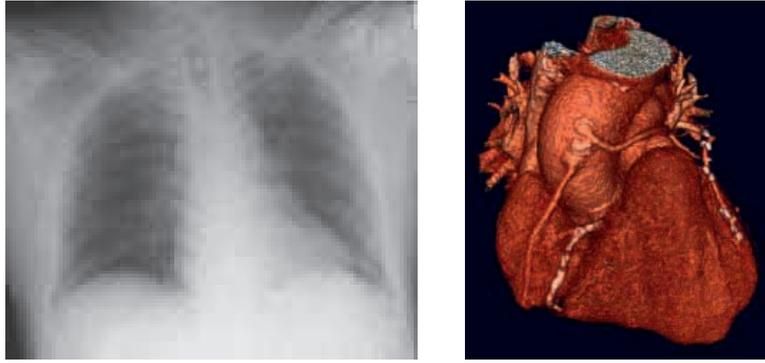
The Homer Simpson syndrome of the modern cardiologist. The evolution of technology in the last 30 years is best represented with the transition from chest X ray (left panel) to 64-slice CT (right panel). However, technology evolution was not matched by evolution in awareness and — like Homer — the contemporary cardiologist knows very little about doses, ignores risks, and neglects appropriateness of imaging testing.*
